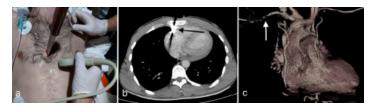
a) Evaluation with FATE in the emergency room,b) Right ventricular injury, CT angiography (black arrow),c) Right subclavian gunshot injury, CT angiography, 3D imaging (white arrow)
